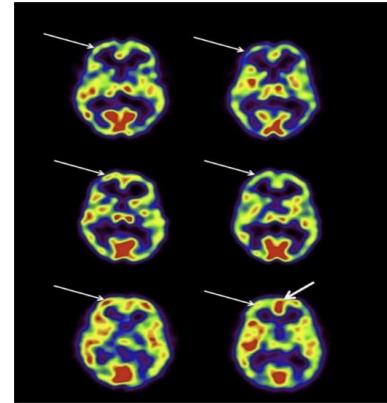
The SPECT scan shows participants in their control state (left column) compared to one in intensive prayer (right column). The arrows point to a decrease in frontal lobe activity in all three participants, and an increase of the anterior cingulate gyrus activity in only the third individual under intense salat [3].
